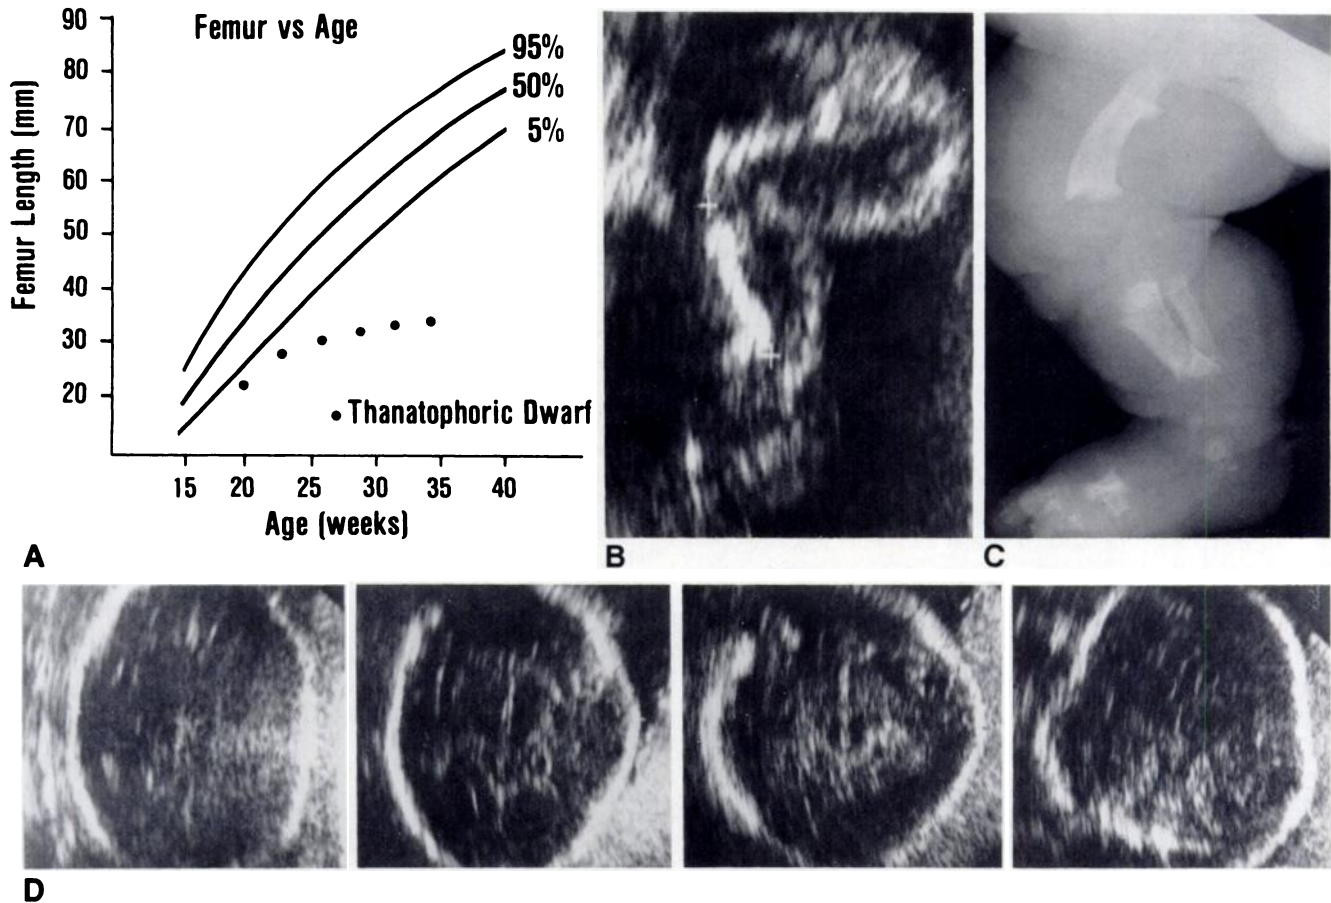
A, Femur length measurements from 19.7 to 34.5 weeks gestation in fetus with thanatophoric dysplasia show grossly abnormal growth pattern. (Values for normal fetuses are from [5, 6].) B, Sagittal sonogram of leg at 22.6 weeks showing abnormally short, thick bones and soft tissues. C, Lateral
